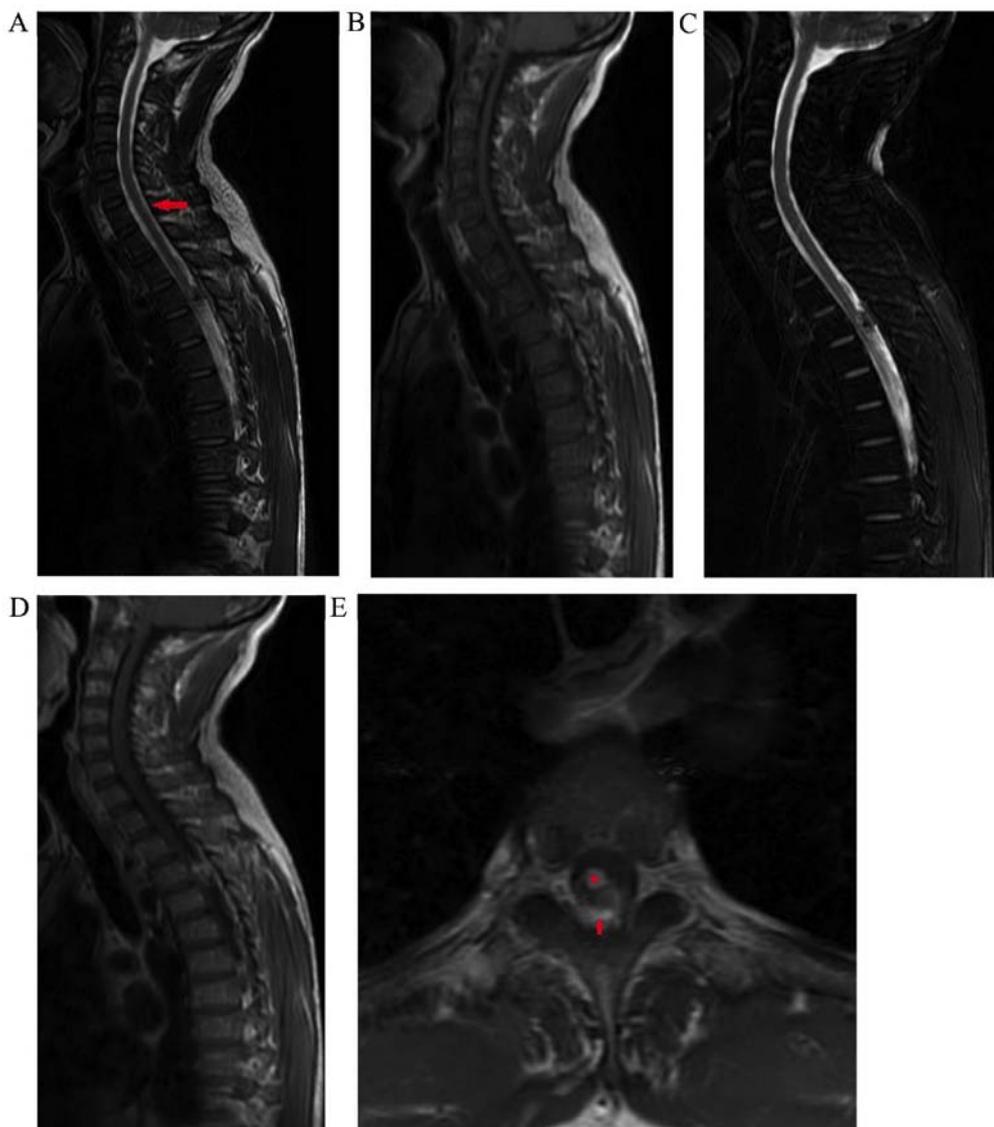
MRI images before the first operation. (A) Sagittal T2-weighted image (TR 3200, TE 124.3). The arrow indicates the linear signal corresponding to dura. (B) T1-weighted image (TR 2860, TE 17.6) and (C) Short T1 Inversion Recovery (TR 3200, TE 124.3) showing an intradural extramedullary mass at T3 level. (D) Sagittal (TR 2860, TE 17.6) and (E) axial (TR 420, TE 12.2); the star indicates the intradural mass, while the arrow indicates the extradural mass) images indicate that the mass is slightly enhanced after administration of gadolinium. TR, repetition time; TE, echo time.
